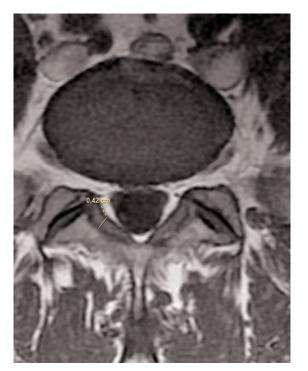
Measurement of the ligamentum flavum thickness on axial T1- weighted MR images at the facet joint level.
